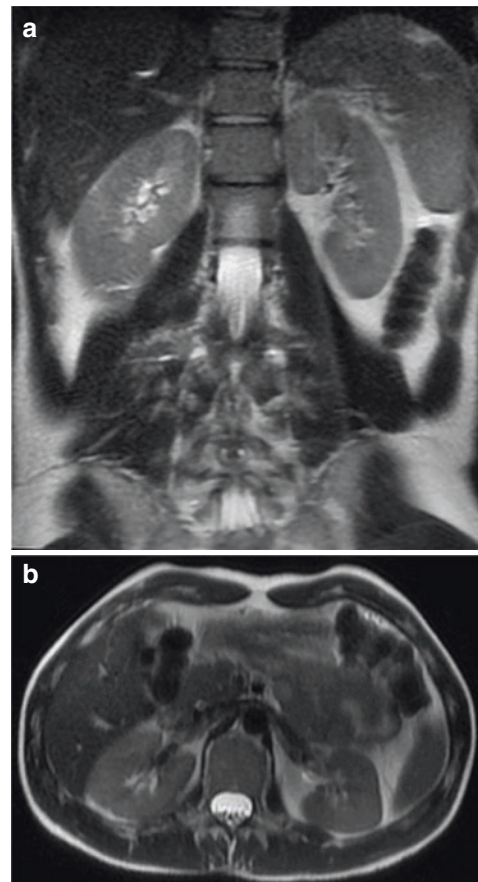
Magnetic Resonance Imaging (MRI) of normal kidneys. Coronal (a) and Axial (b) T2-weighted MRI of the normal kidneys
